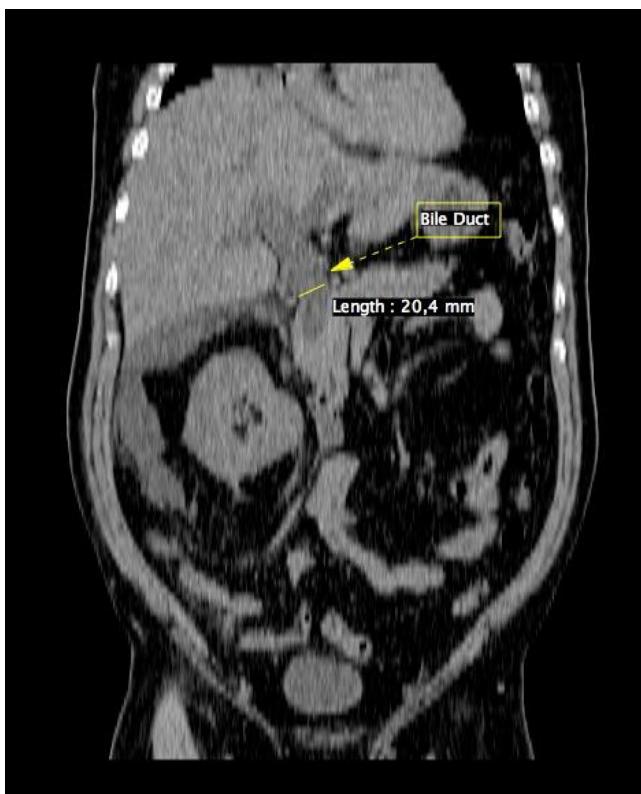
CT scan coronal section. It shows dilation of the intra and extrahepatic biliary tract, as well as free fluid, in the right parieto-colic gutter.
